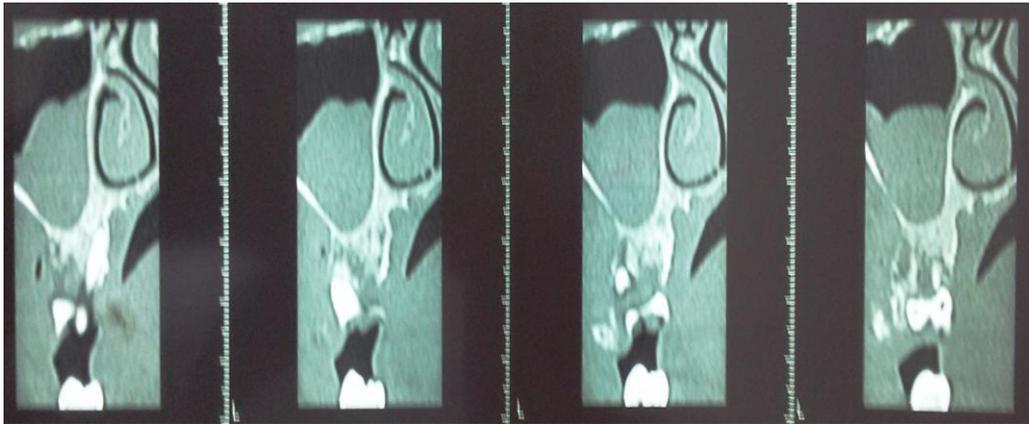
Cone-Beam Computed Tomography (CBCT) of the Maxilla.
